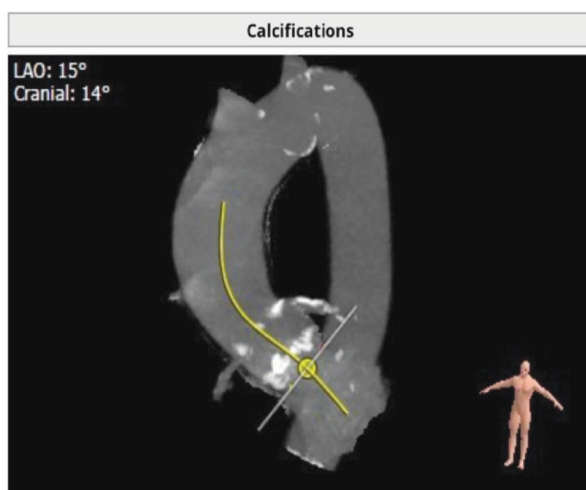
CT of aorta, patient No 3
